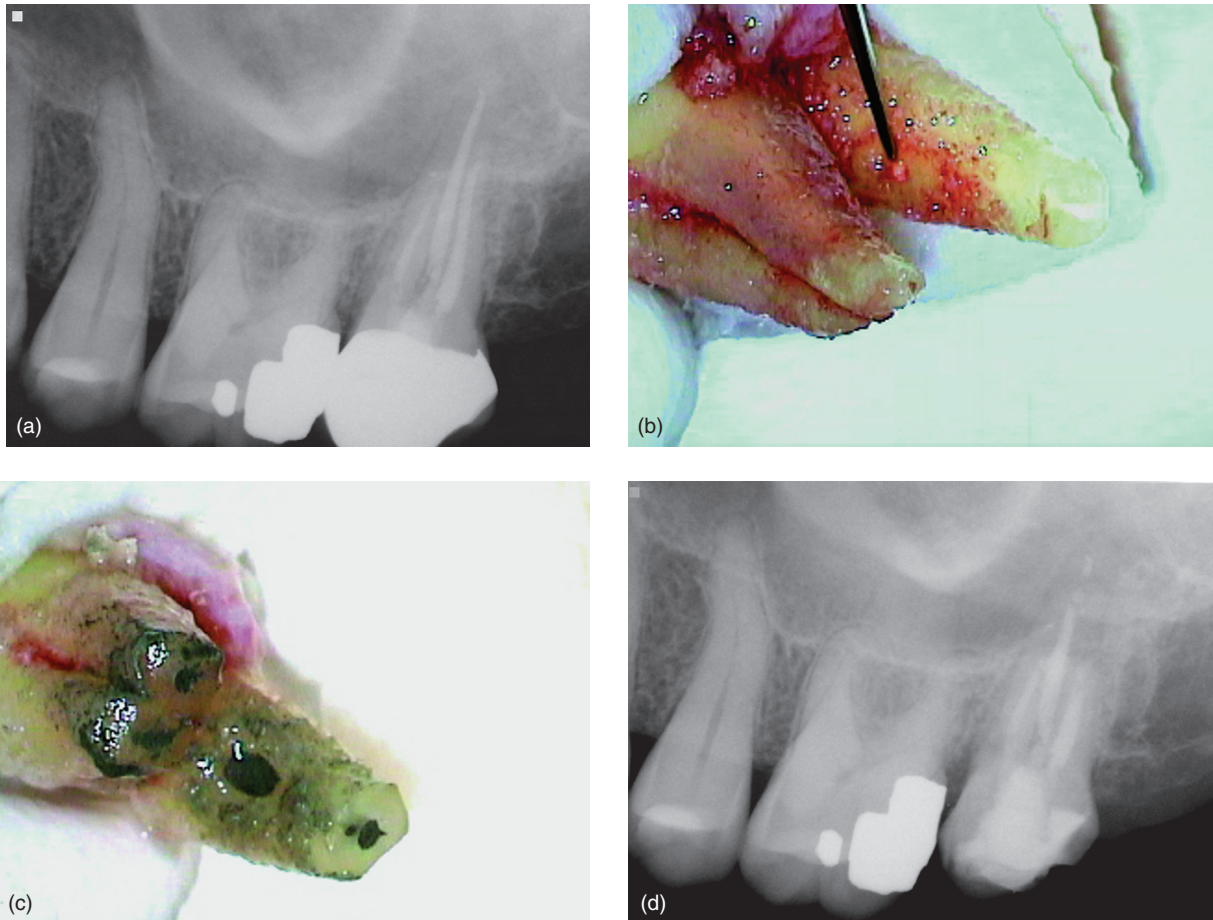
Maxillary left second molar with previous endodontic treatment that was always symptomatic and unable to diagnose the source. (a) Preop radiograph; (b) perforation discovered on the furcal side of the palatal root in the mid-root region; (c) root end preps and perforation prepped and filled with grey MTA; (d) postop radiograph.
